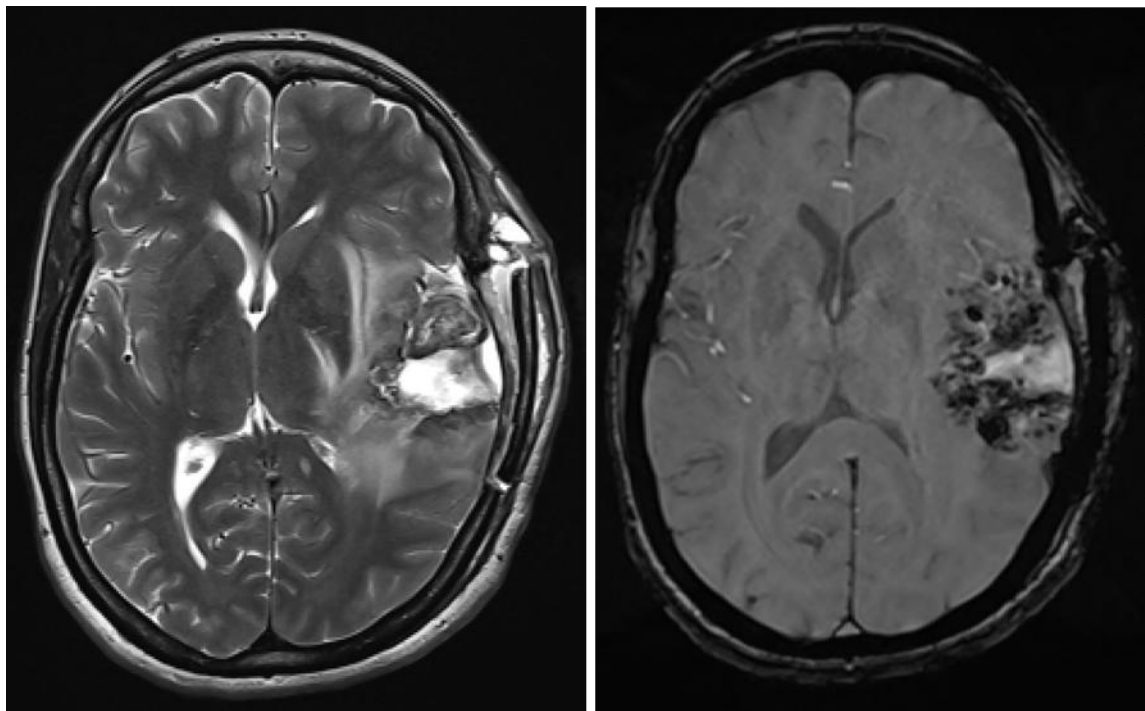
Postoperative MRI brain. Postoperative MRI brain showing near-complete excision of the left fronto-temporo-parietal/perisylvian lesion with residual perifocal edema and mass effect. The right cerebellar lesion showed features suggestive of resolving hemorrhagic infarct.
